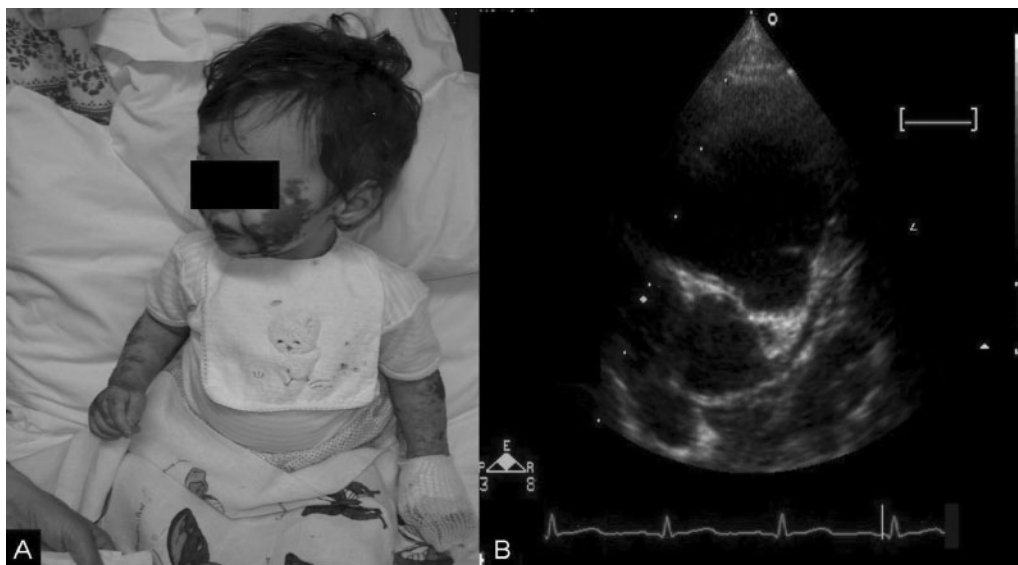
(A) A 17-month-old boy with the Kawasaki disease: extensive cutaneous crusts all over the body. (B) Echocardiographic finding of dilatation of the left coronary artery.
